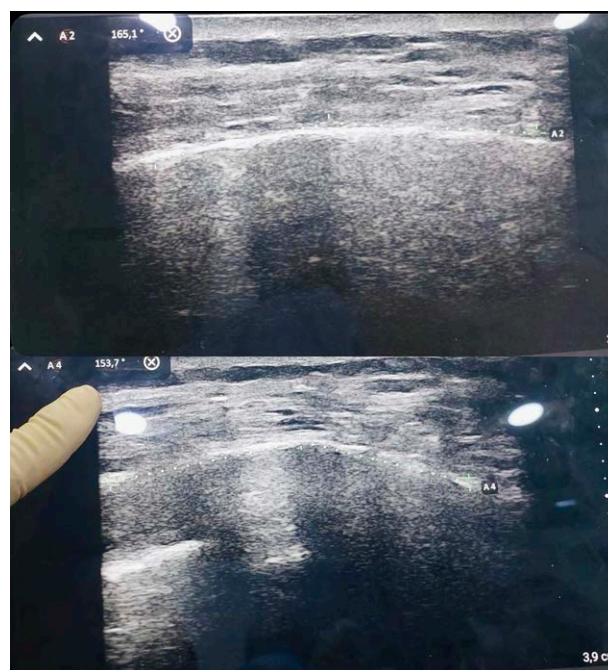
Ultrasound pre- and postsurgery.
